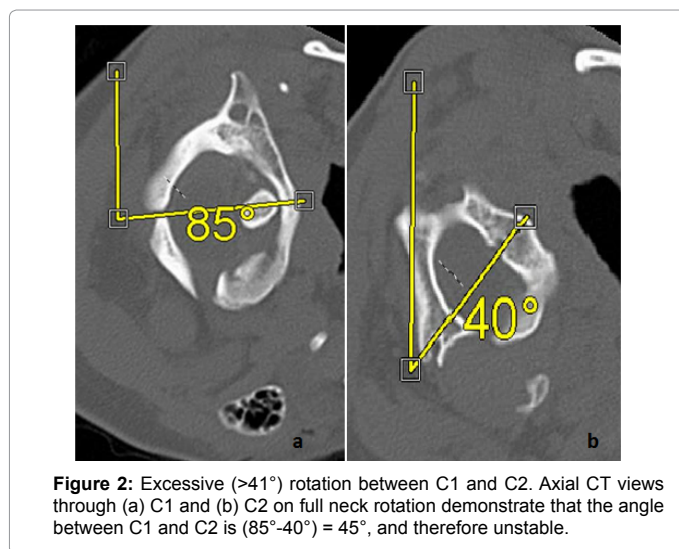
Excessive (>41°) rotation between C1 and C2. Axial CT views through (a) C1 and (b) C2 on full neck rotation demonstrate that the angle between C1 and C2 is (85°-40°) = 45°, and therefore unstable.
